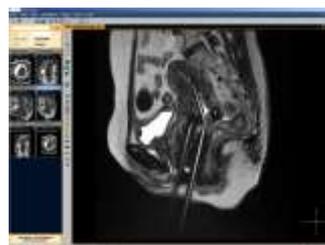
MRI with Vienna ring applicator in situ. The cervix, uterus, bladder, rectum and small bowel can be visualised clearly to allow for accurate dosimetric planning and radiation dose optimisation.
